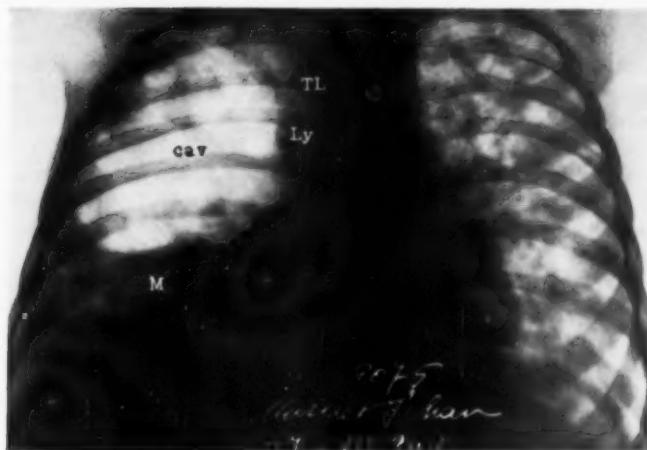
Radiography of the Case Demonstrated in Fig. 13.
